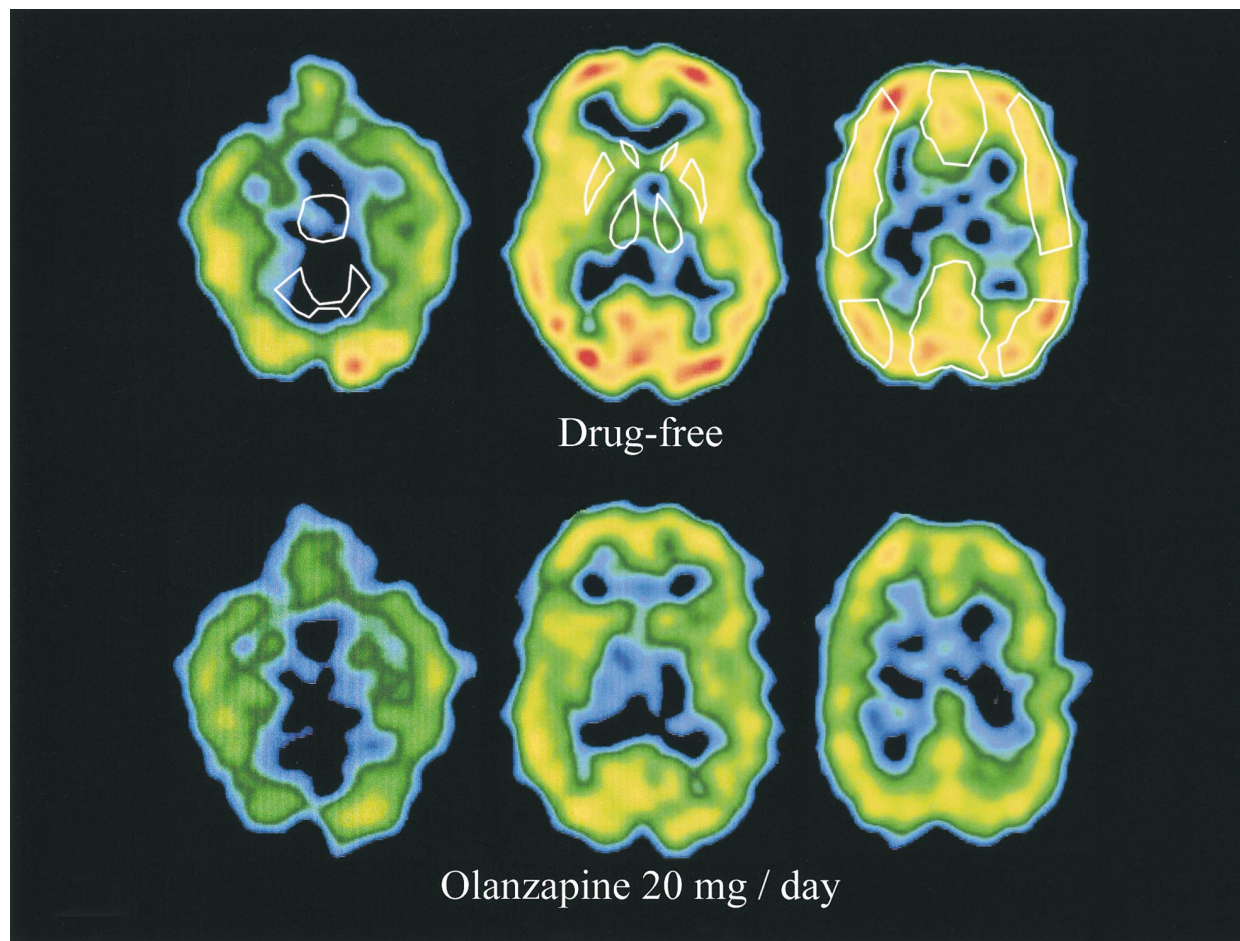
Typical [$I-123$]IQNB SPECT scans of a medication-free patient (upper) and a patient treated with olanzapine 20 mg/dy (lower) at the levels of pons (left), the basal ganglia and thalamus (center), and dorsolateral cortex (right). Regions of interest (ROI) are shown for the medication-free SPECT images.
